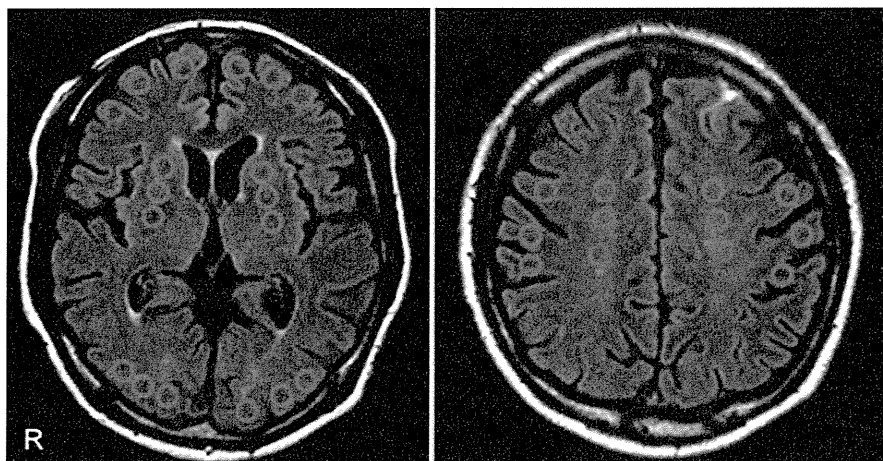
Regions of interest (ROIs) on fluid-attenuated inversion recovery (FLAIR). The small circular ROIs (10 mm in diameter) were placed on the frontal cortex, parietal cortex, occipital cortex, basal ganglia, and the centrum semiovale based on FLAIR image.
